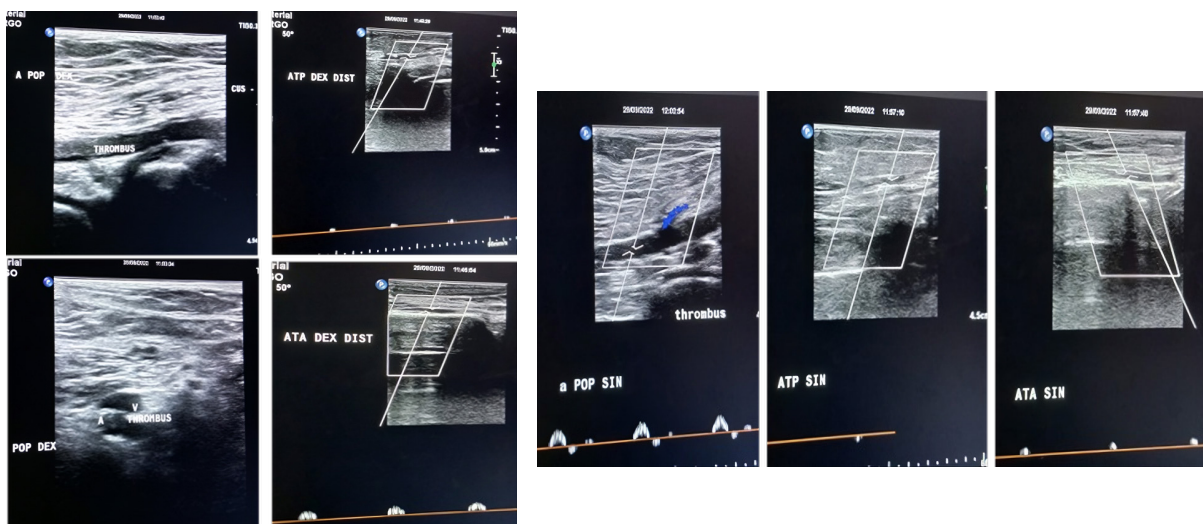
Duplex ultrasound of the lower limb showed fresh thrombus in the bilateral popliteal arteries. The flow is diminished in the distal artery in both legs.
